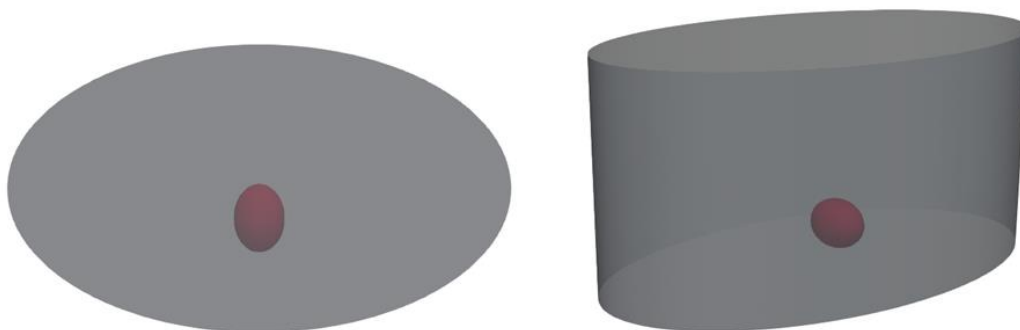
Solid format of the designed anatomically-informed forward model. The model is shown from a 2D top view (left) and a 3D perspective view (right). Similar to bladder in the example CT scans in Figure 3.2, the bladder is situated off-centre to the anterior of the model.
